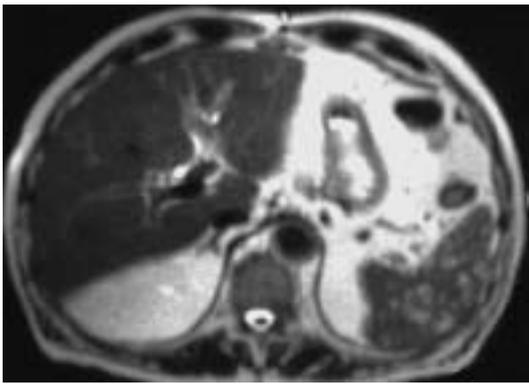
MRI: multiple hypointense lesions in the spleen (T₂).
